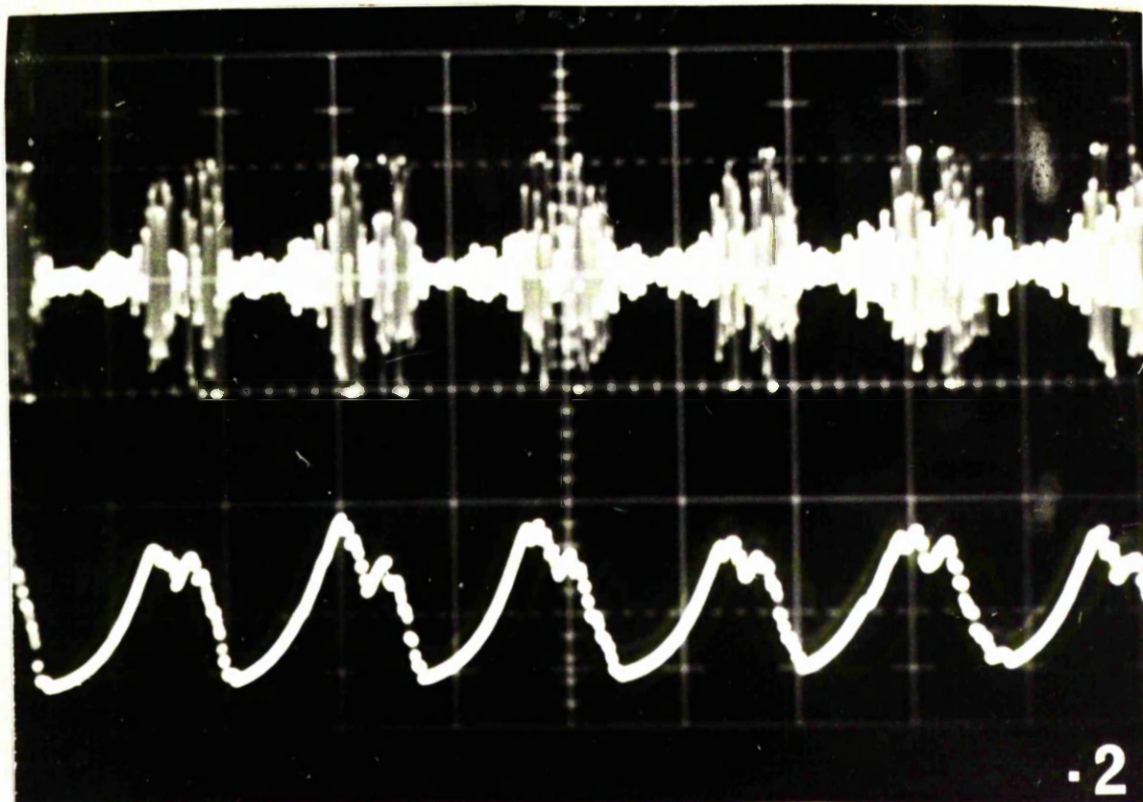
Output of ultrasonic Doppler unit before
